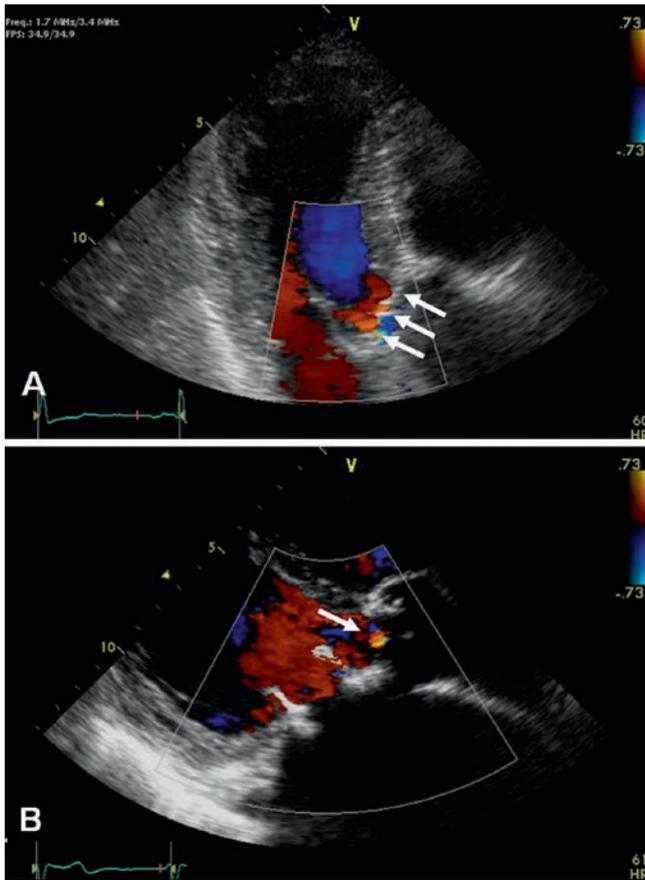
Colour Doppler imaging during diastole showing the normal appearance of three “physiologic” regurgitant jets (“leakage backflow,” white arrows) from a bileaflet valve (a) and a bioprosthesis (white arrow, b) in aortic position
